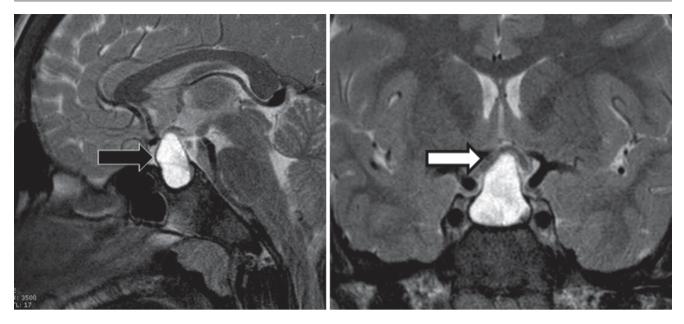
Magnetic resonance imaging (MRI) appearance of Rathke's cleft cyst (RCC), with sagittal (a) and coronal (b) T2-weighted images. Note lesion rising out of sella (*black arrow*) and compressing optic chiasm (*white arrow*)
